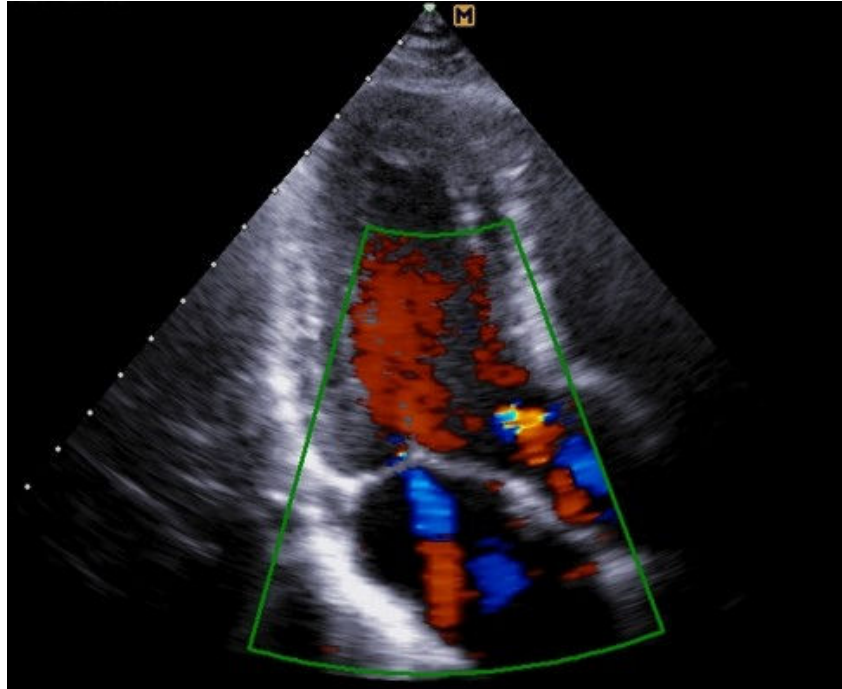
Right-upper panel*: Parasternal long-axis view. *Right-upper panel*: Parasternal short- axis view. *Left-lower panel*: Apical four-chamber view. *Right-lower panel*: Apical two-chamber view [10].
